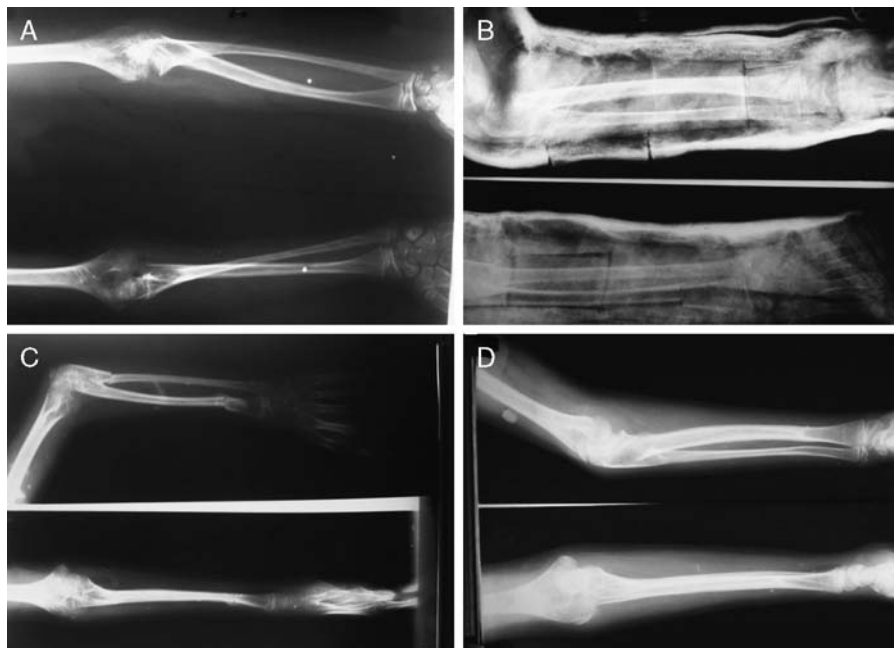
A, Presurgery radiograph of the child suggesting proximal radioulnar synostosis. B, Postsurgery radiograph showing osteotomy of the radius and ulna with cast in situ. C, Radiograph after 5 weeks suggesting early union at osteotomy sites. D, Radiograph at subsequent follow-up showing good remolding at osteotomy sites.
